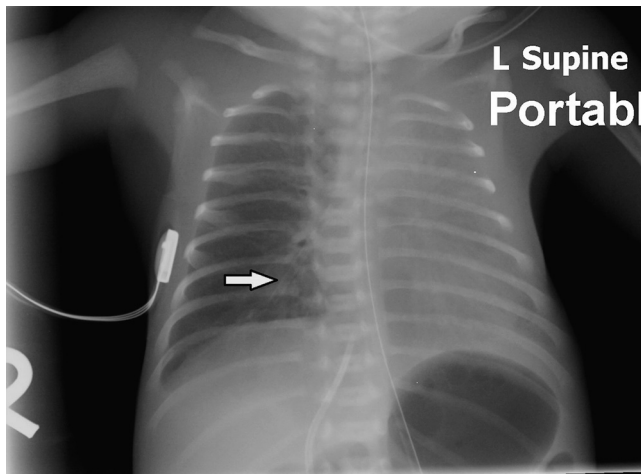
Anteroposterior chest X-ray shows a foreign body at right bronchus (Arrow points to the foreign body).
